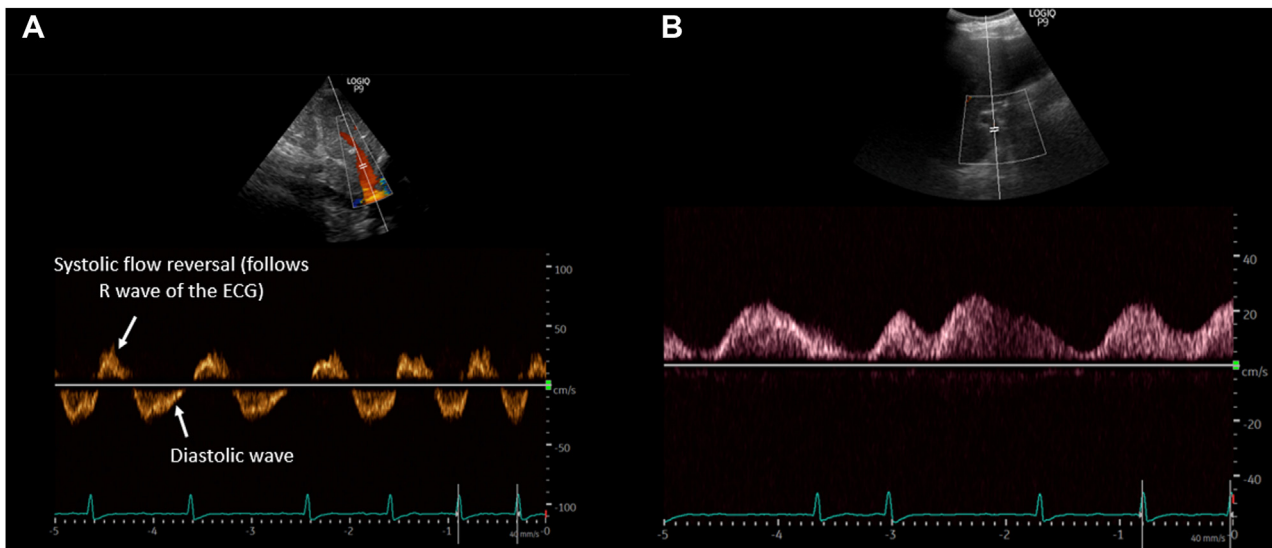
Lower extremity 2D-guided color-flow and pulsed-wave Doppler examination of the right common femoral vein demonstrates a pulsatile (to-and-fro) spectral waveform pattern typically associated with severe venous congestion.
